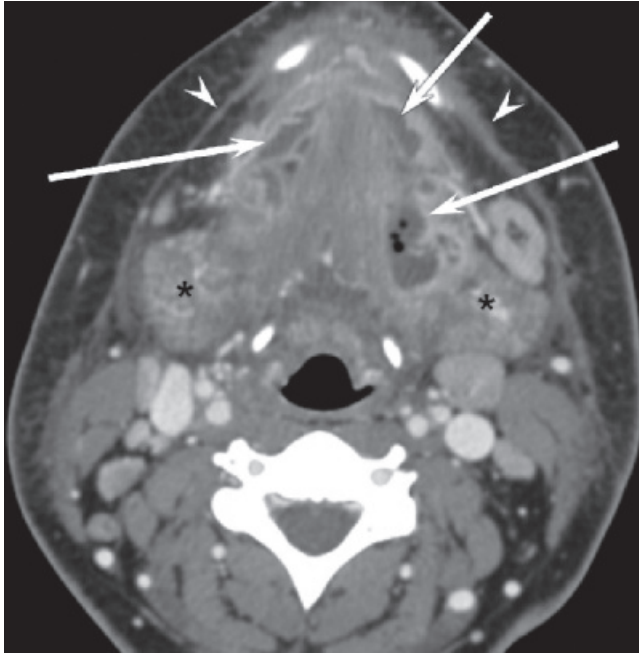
Ludwig angina. Axial contrast-enhanced CT shows diffuse infiltration of the fat planes in the submandibular, submental, and subcutaneous spaces. The platysma muscles (*arrowheads*) are thickened. The submandibular glands (*asterisks*) are inflamed. There is an extensive abscess (*arrows*) throughout the submandibular and submental spaces, with air locules indicating anaerobic infection.
